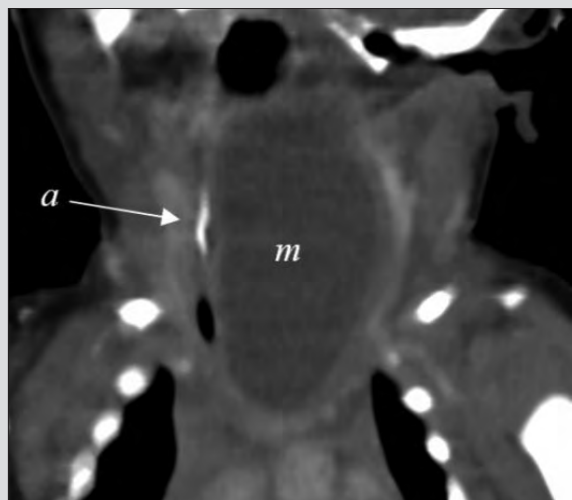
CT images showing a cystic lesion (*m*) extending posteriorly from the anterior mediastinum to the prevertebral space and superiorly into the hypopharyngeal region with a homogenous fluid layer and air pocket (*b*) causing prominent esophageal (*a*) and tracheal (*c*) deviation.
